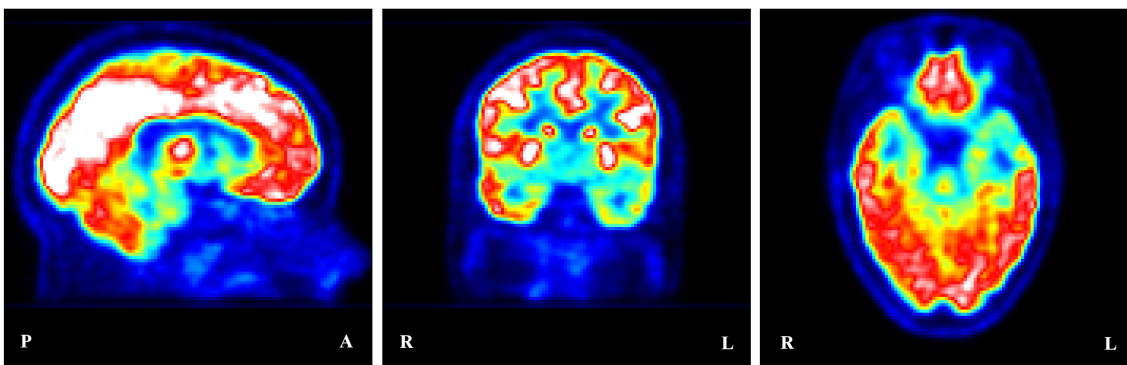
FDG-PET showing left fronto-temporal hypometabolism. Red and white regions show higher glucose consumption in comparison to blue regions.
